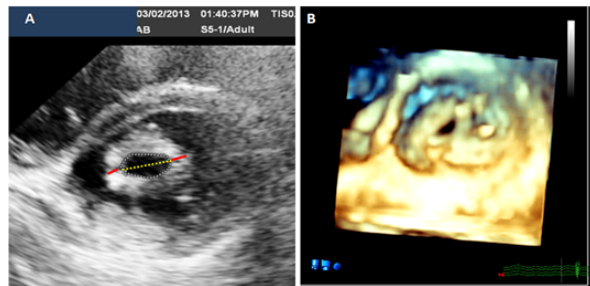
Parasternal short axis view (A) 2D echo Red lines showing measurement of commissural thickness at the margins of mitral orifice. Commissural thickness score was obtained by adding the thickness of medial and lateral commissures (KCD); Yellow dotted line; Intercommissural distance measured from inner edge of Medial to inner edge of lateral commissures (B) Enface view of the mitral orifice
